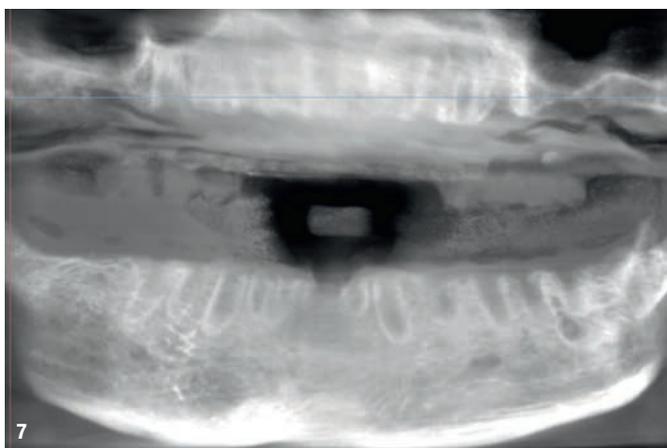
Baseline situation, panoramic aspect obtained by CBCT.
